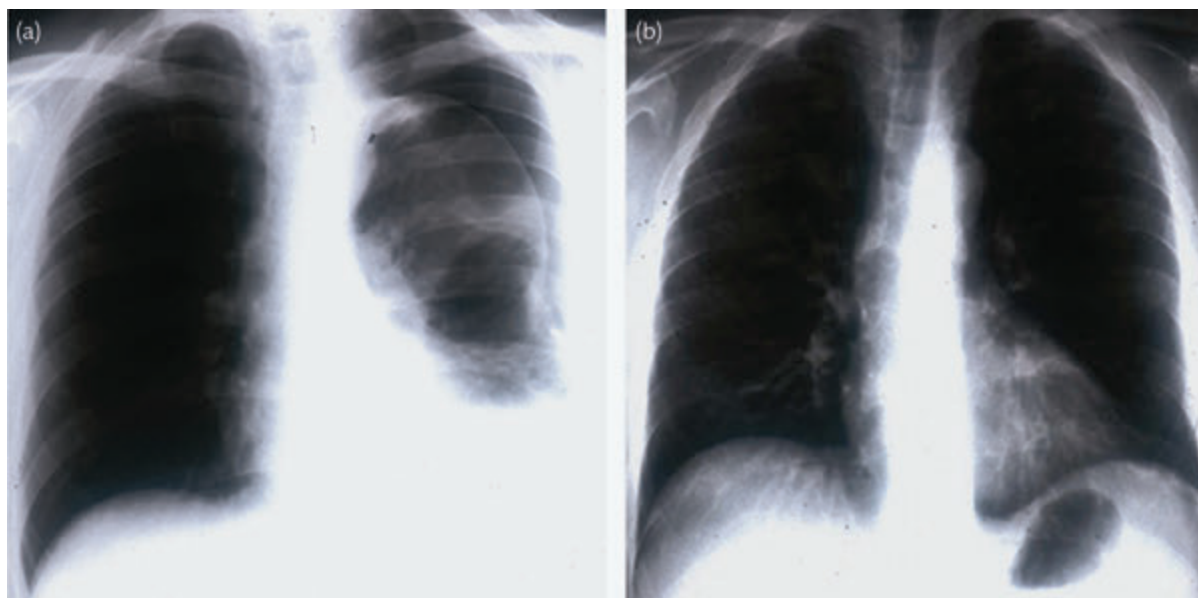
Chest radiographs in a patient with a left lung that has not re-expanded due to visceral pleural thickening following drainage and treatment of a pleural infection (a). The patient was clinically well and the radiographic changes resolved spontaneously over 3 months (b).
